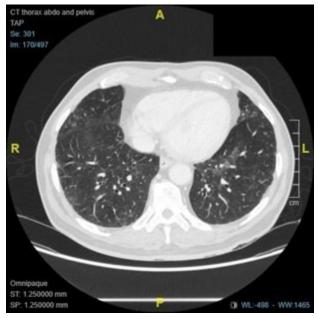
Baseline CT Thorax pre-treatment
